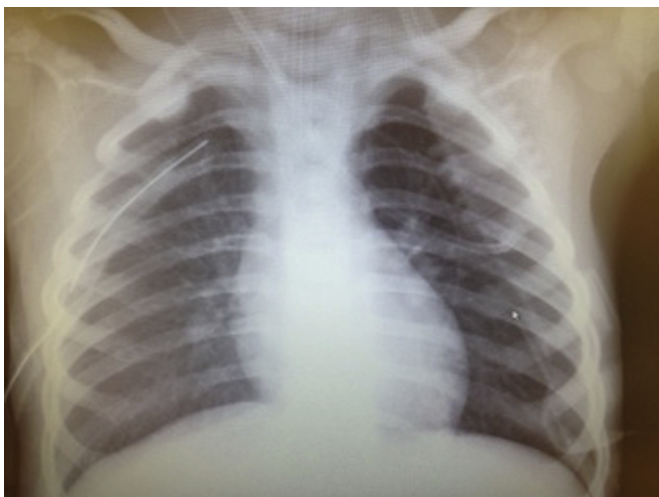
Chest x-ray after tube thoracostomy.
